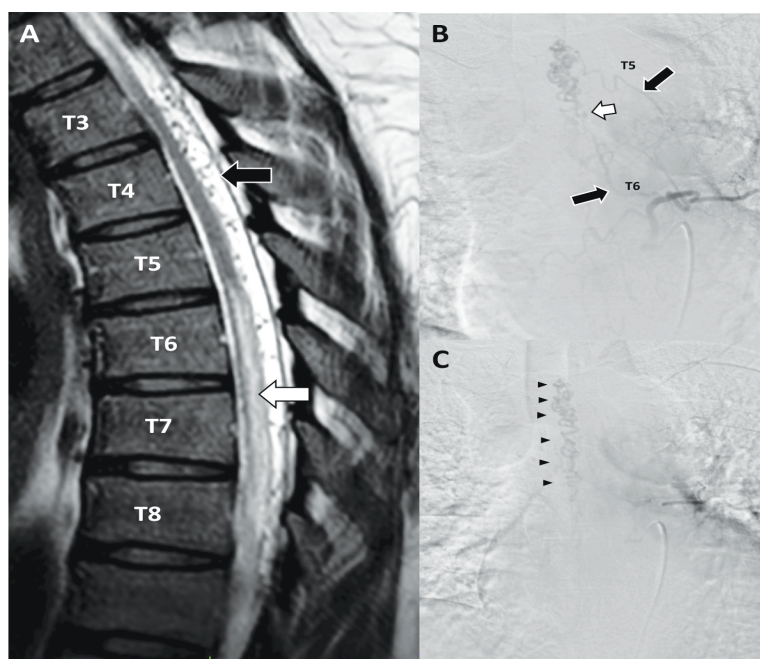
A: T2-weighted MRI of the sagittal thoracic spine revealed centromedullary hyperintensity extending from T5 to the conus (white arrow), accompanied by dilated perimedullary vessels (black arrow). These findings are characteristic of spinal dAVF.
